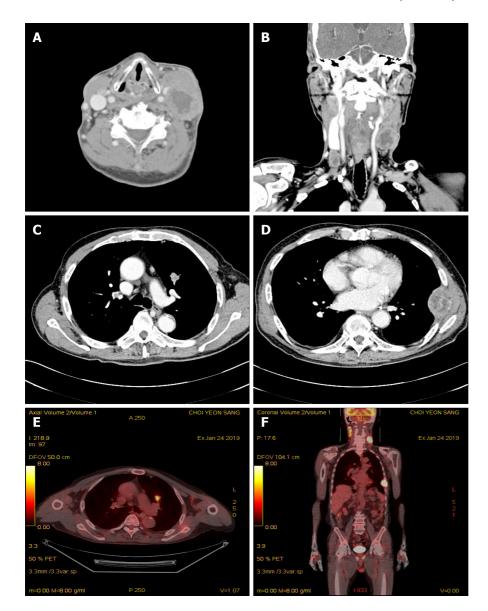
Contrast-enhanced neck computed tomography, contrast-enhanced chest computed tomography, and ¹⁸F-fluorodeoxyglucose positron emission/computed tomography. A: 41 mm × 64 mm sized bulky necrotizing lymphadenopathy in left cervical level V; B: Multiple various sized necrotizing lymphadenopathy on both cervical level II to V; C: Contrast-enhanced chest computed tomography shows 2 cm sized heterogeneous enhanced nodule in anterior segment of left upper lobe (LUL); D: Large periosseous mass formation involving lateral arc of left 7th rib; E: 18F-fluorodeoxyglucose positron emission/computed tomography showed a hypermetabolic nodule in LUL; F: Multiple enlarged hypermetabolic mass on both cervical level II to IV, and hypermetabolic mass on left 7th rib.
